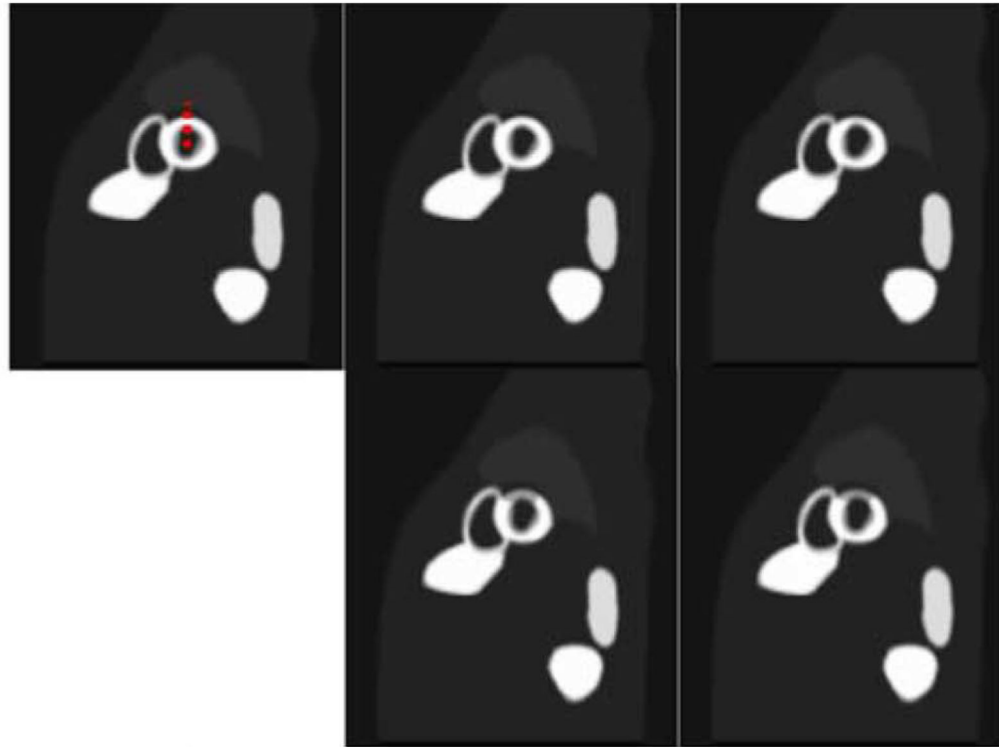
Intensity profiles (bottom) across the anterior region (red dashed line) of the LV taken from short-axis images (top) indicate that the remodeled defect based on the FE model shows the greatest reduction in intensity with respect to the normal both with full perfusion and the 50% reduction in perfusion. The full perfusion fibrous infarct is indistinguishable from the normal but represents a case never found clinically. The 50% reduction in perfusion results in difficulty in distinguishing between the fibrous and remodeled cases due to the low resolution of the reconstructed gated SPECT images.
